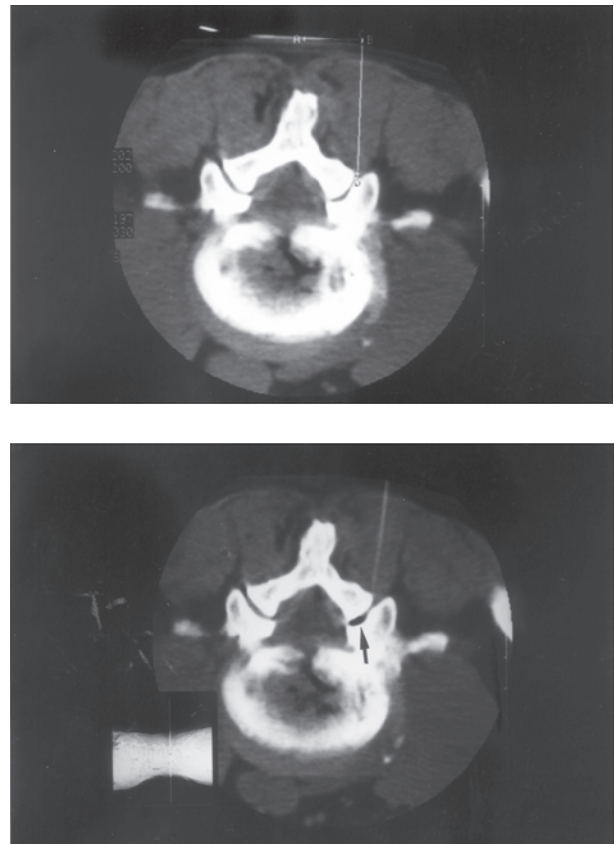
The CT-guiding facet injection technique. First, measured the distance from a skin entry point to the mid-spinal line and to the joint (A). Inserted the needle to the desired depth then injected with 0.5 ml air, both were confirmed by single CT scanning. After identification of air in the joint (Arrow in B) by CT monitor, 1.5 ml of local anesthetic and steroid was slowly injected.
